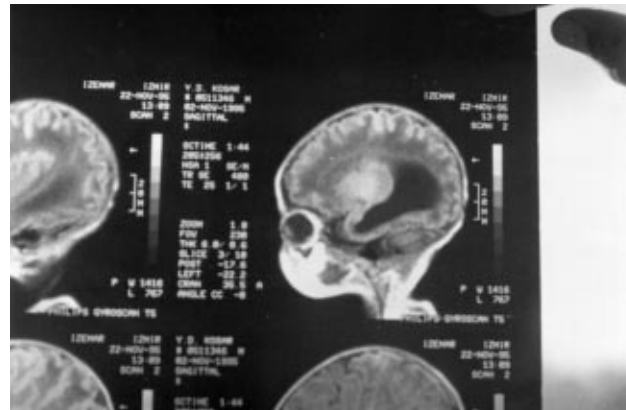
Cranial MRI findings of our patient. Note the enlargement of the occipital horns of lateral ventricles (colpocephaly) and the agenesis of corpus callosum.
